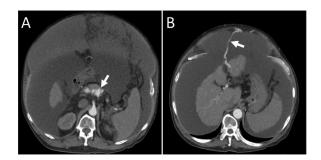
(A, B) Arterial-phase contrast-enhanced CT, obtained 1 year after the angiography results shown in Figure 1, demonstrating massive ascites. Enhancement of the dilated venous space (arrow in A) of the pancreatic AVM is shown and a patent paraumbilical vein (arrow in B) is observed.
